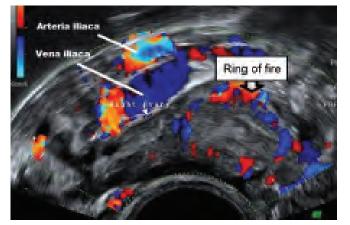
Color Doppler image demonstrating "ring of fire" encircling the corpus luteum
